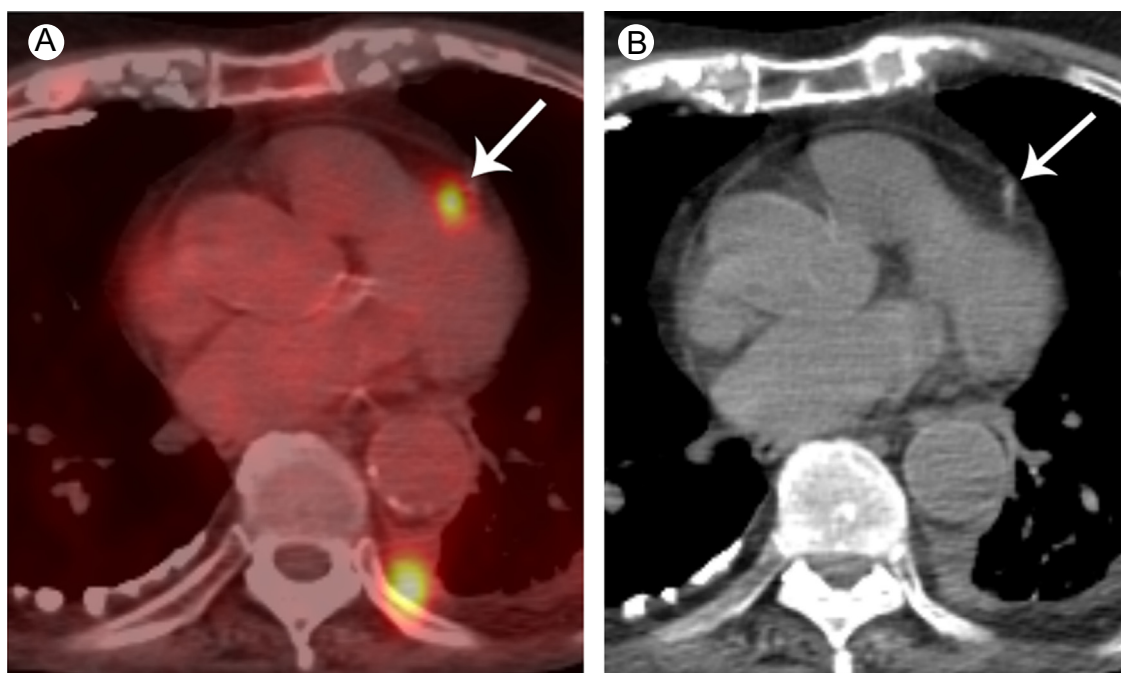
FDG PET-CT scan of an 80-year-old man with multiple recurrent squamous carcinomas of the head and neck. Fused FDG PET-CT scan (A) at the level of the heart shows focal FDG uptake (arrow) abutting the heart but careful inspection of the accompanying CT (B) shows that this uptake is localized to the left anterior descending coronary artery, due to inflammation associated with atheromatous changes. (Color version of figure is available online.)
